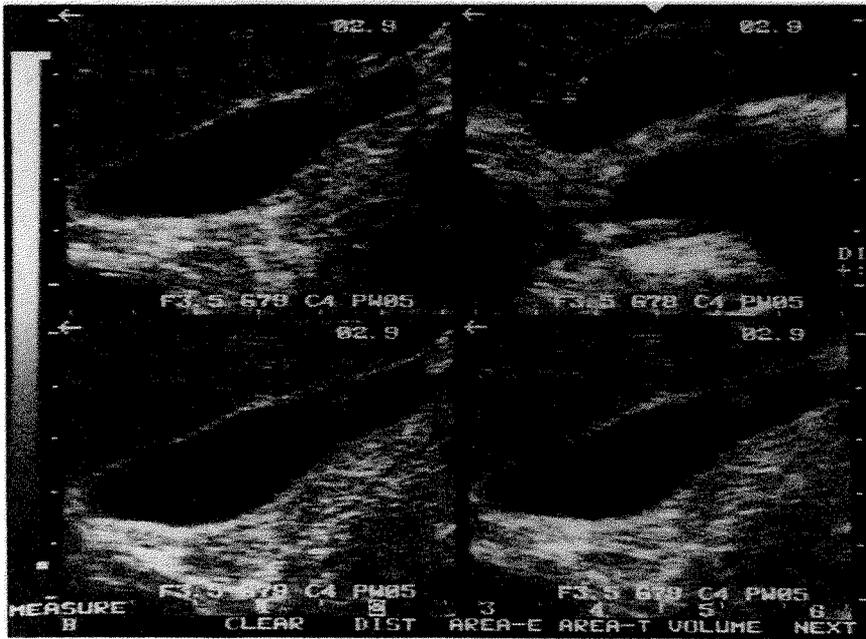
M.R., 17 years, male — Ultrasonographic findings (above), and cholecystographic and gross pathologic appearances (below) of a 0.4 cm adenomatous polyp of the gallbladder are presented.
